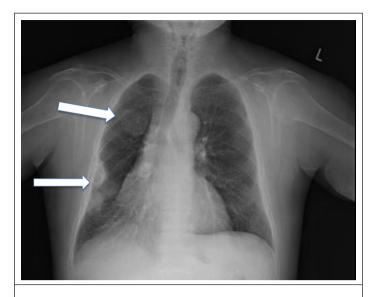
Multiple opacities on chest x-ray.
